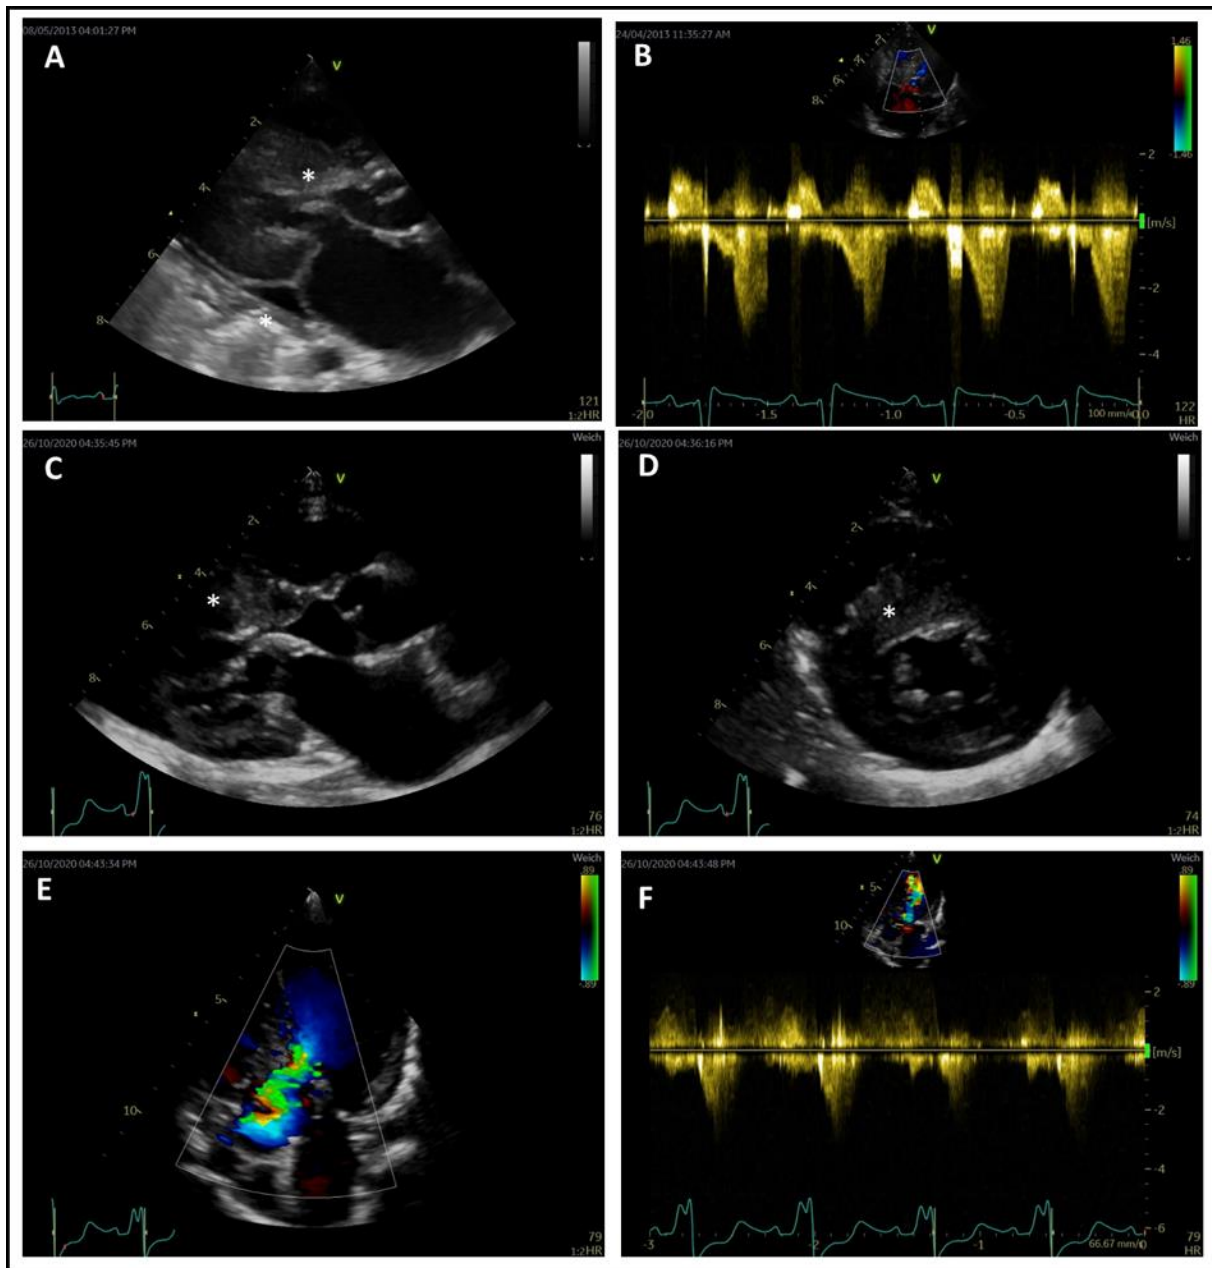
Echocardiographic images of patient 2, Related to Figure 1. Transthoracic echocardiographic imaging of patient 2 (Noonan syndrome, *RAF1*, female, 12 months of age) at the time of admission to the hospital for surgical left ventricular outflow tract resection (panel A and B), and at the time of follow-up (101 months of age, panel C, D, E and F). Depicted are the parasternal long axis view (panel A and C), parasternal short axis view (panel D), and the apical 5-chamber view (panel B and E) with color Doppler (panel E) and continuous wave (CW) Doppler (panel B and D) imaging. There is severe myocardial thickening (*), the peak gradient over the left ventricular outflow tract measures 75 mmHg before resection of the left ventricular outflow tract (panel B), and 40 mmHg at the time of follow-up (panel F).
